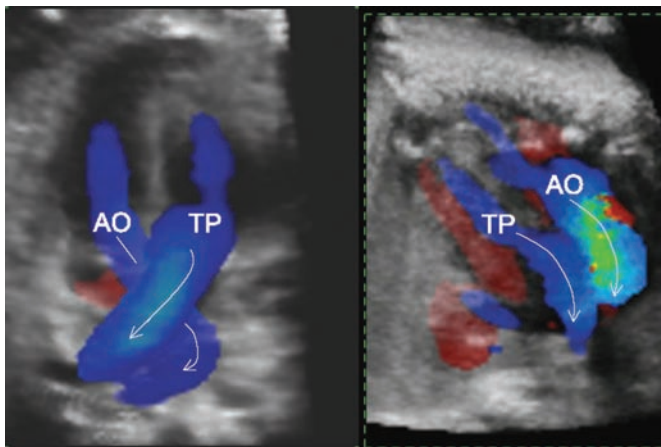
3D and 4D volume rendering with transparent gray scale and surface color Doppler of two fetuses: on the left a normal finding with the regular crossing of the great vessels, on the right a fetus with transposition of the great arteries with parallel course of both vessels.
